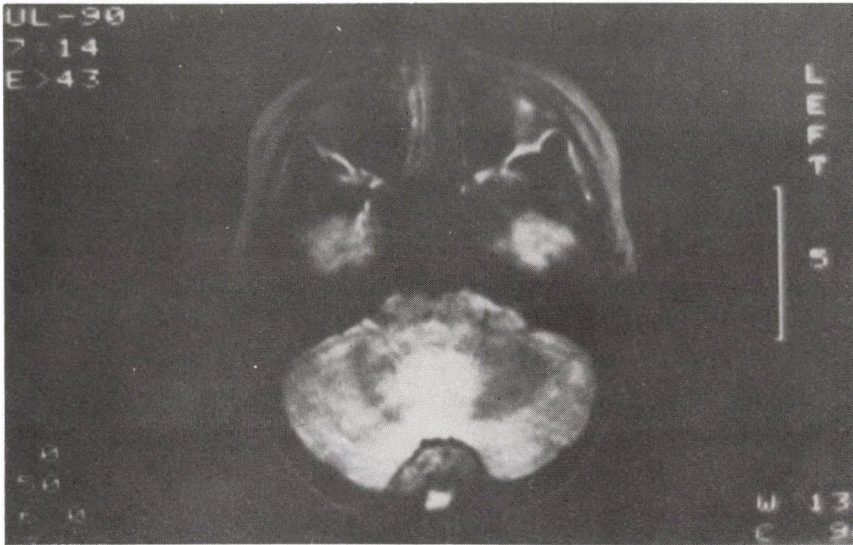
Magnetic Resonance Imaging shows a high-density tumour in the occipital area
